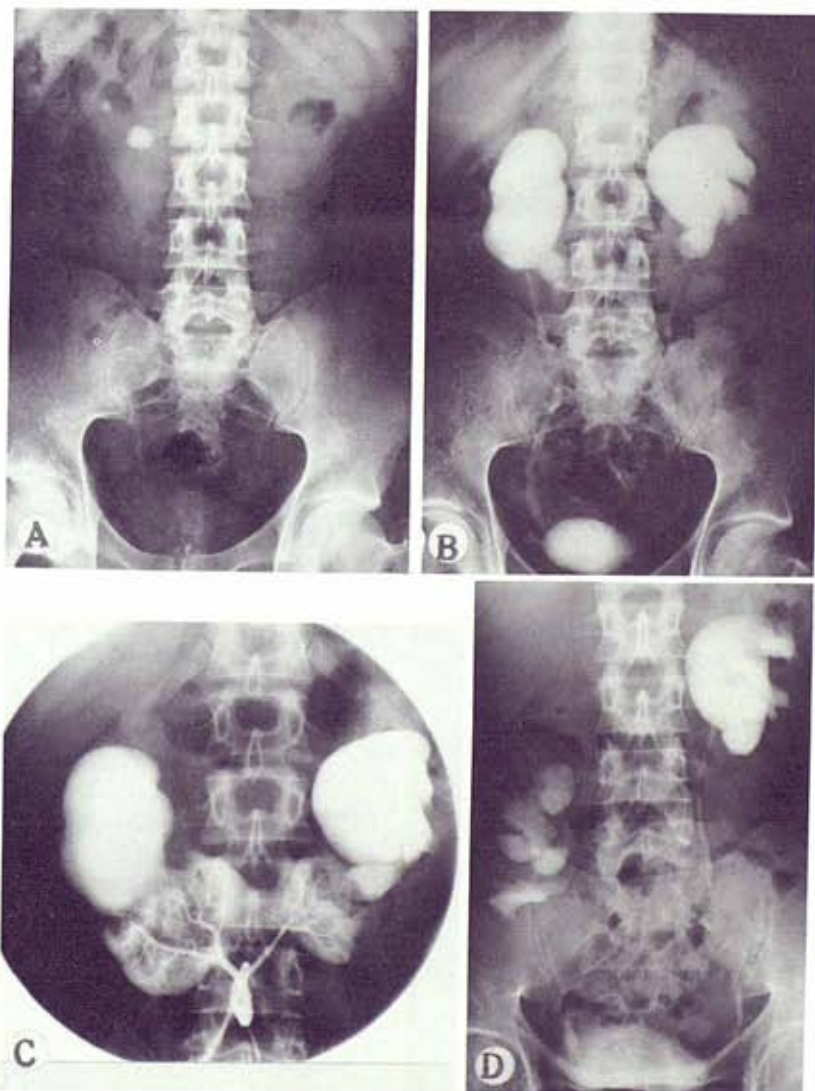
Case 6. *A*, x-ray reveals lithiasis in horseshoe kidney. *B*, marked bilateral pyelocaliceal dilatation. *C*, aortography and selective arteriography of artery of renal isthmus are of great interest in this operation. *D*, IVP after right heminephrectomy, bench surgery and autotransplantation.
